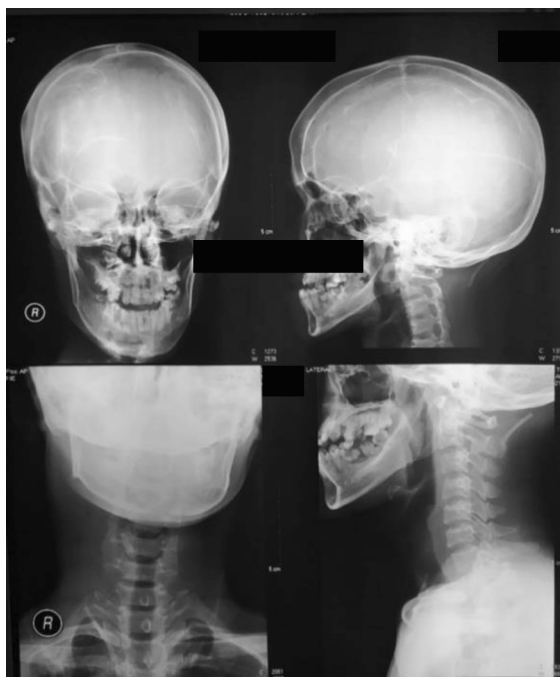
Dysfunction of the shunt in the neck region at C7 segment level on skull and cervical spine x-ray.
